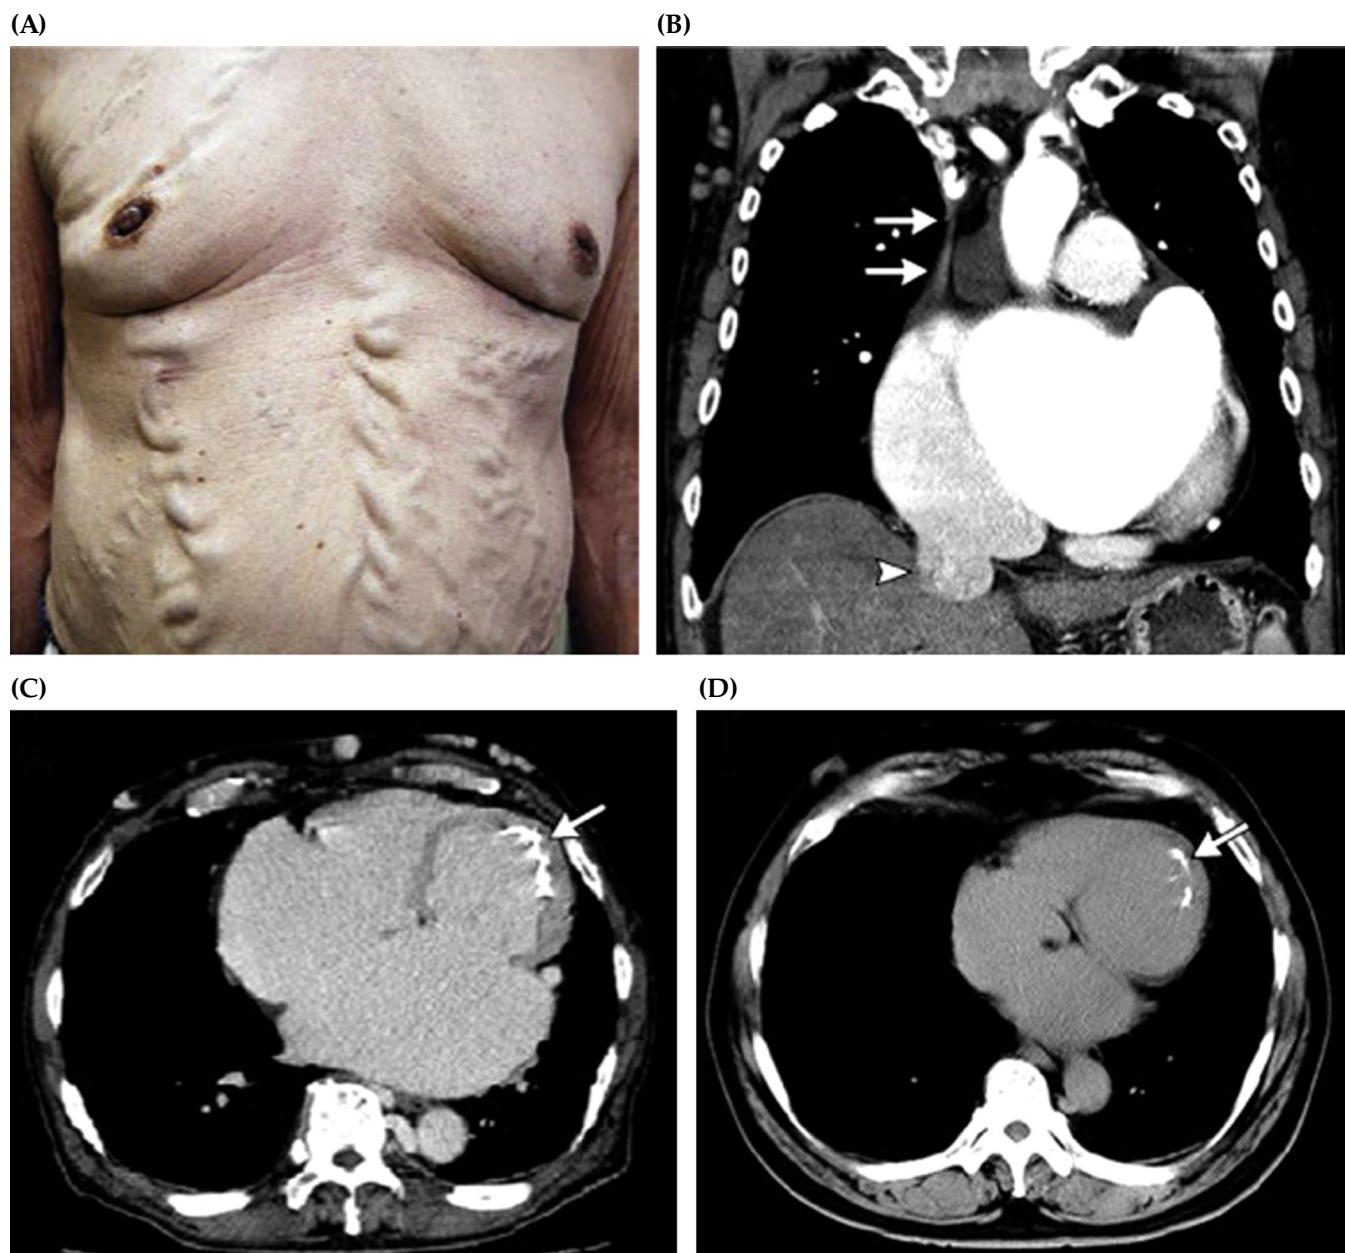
Nishida and Hakuno [84] reported the case of a 68-year-old man who presented with varices of the chest and abdominal wall (Panel A) due to superior vena cava obstruction (Panel B, *arrows*). Chest CT showed also dilatation of inferior vena cava (Panel B, *arrowhead*). CT scan detected endocardial calcification on the midlateral and apical wall (Panel C, *arrow*), more extensive than that seen on previous imaging performed 11 years earlier (Panel D, *arrow*). Adapted from the personal collection of the authors.
